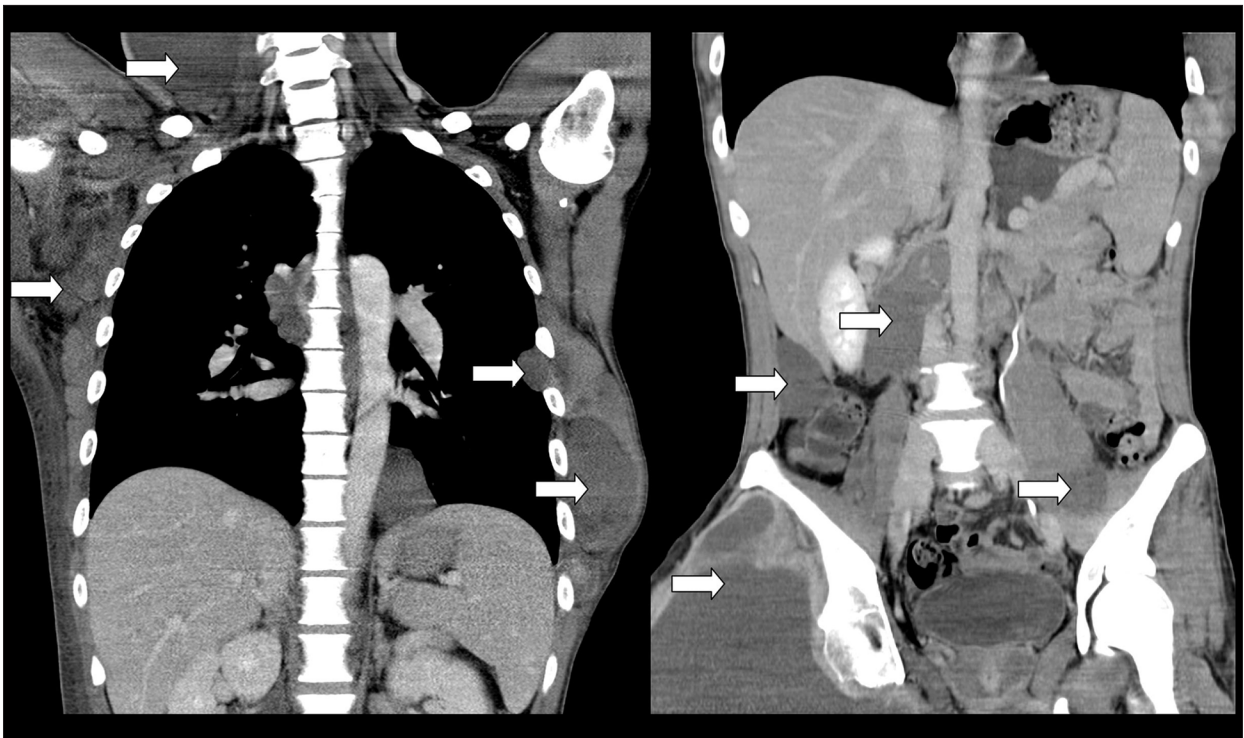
Chest x-ray shows soft-tissue-density mass lesions (arrows) at the right axilla, right neck, and pleural involvement in addition to infiltration of the chest wall.
